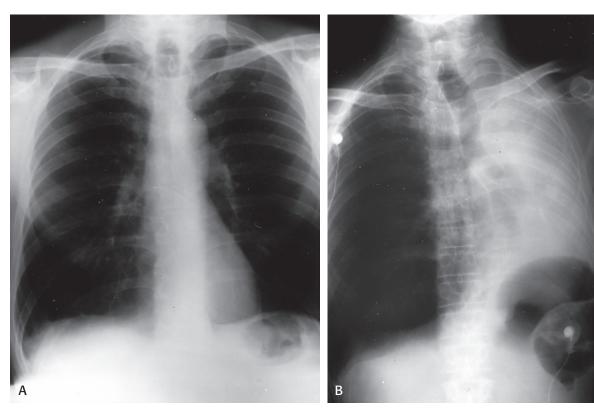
X-ray of atelectasis (a) Normal; (b) Atelectasis. Courtesy of Leonard V. Crowley, MD, Century College.
